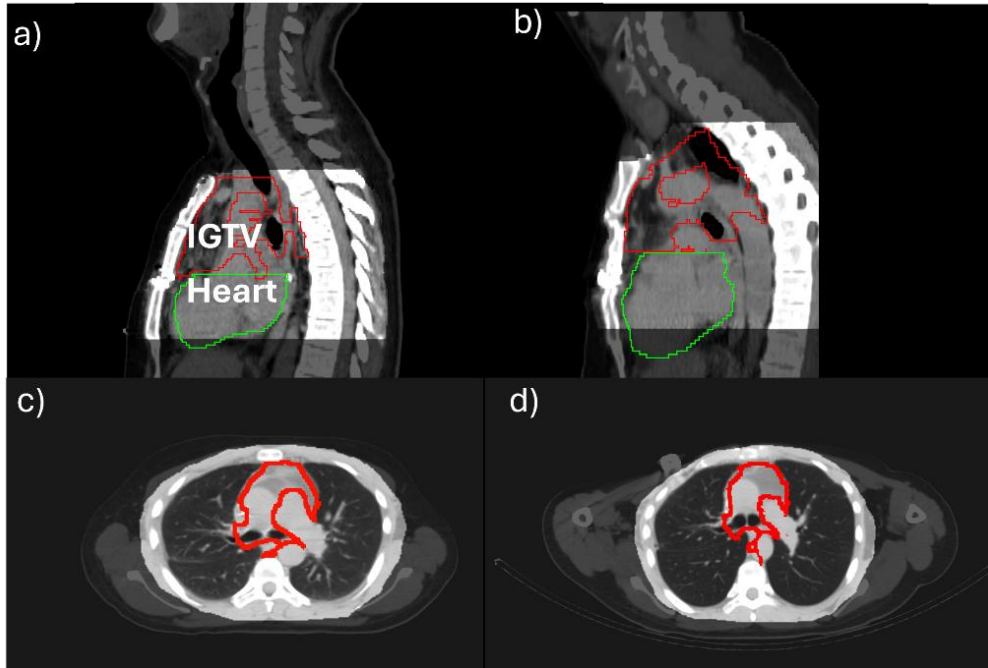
Patient P3 supine (a,c) and upright (b,d) reference CT in sagittal (a,b) and coronal (c,d) view. IGTV (red) and heart (green) contour quality differences are shown (c,d). The registration ROI is superimposed to the reference CT, together with the M.C. and propagated IGTV for the supine (c) and upright (d) case, respectively.
